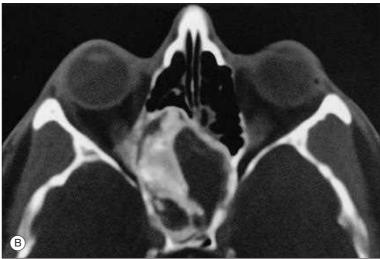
Axial Computed Tomography of the Orbits. (A) Tissue density window. (B) Bone density window.
